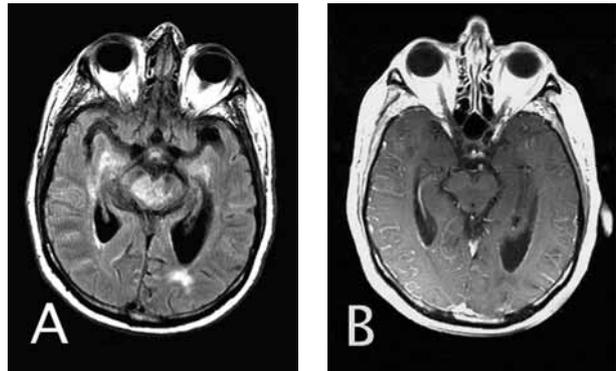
Brain MRI shows brainstem, bilateral medial temporal, and periventricular hyperintensities on FLAIR sequences (A), without gadolinium enhancement on T1-weighted images, in contrast to a marked diffuse leptomeningeal gadolinium enhancement (B).
